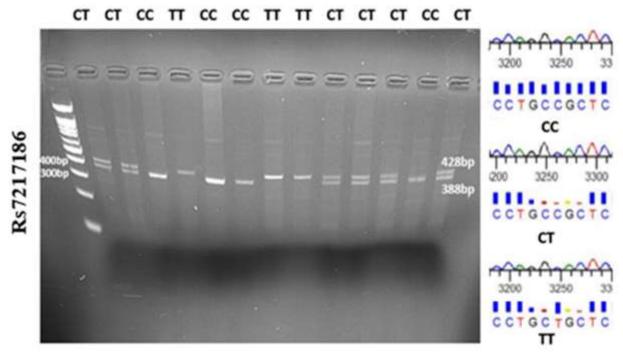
Restriction digestion (MbiI) products of ALOX15 rs7217186 polymorphism on 1% agarose gel: wild CC genotype (388 bp), heterozygous CT genotype (428 bp, 388 bp, and 40 bp), mutant TT genotype (428 and 40 bp), and their corresponding sequencing results.
